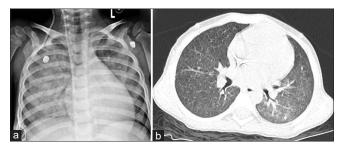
Chest X-ray showing bilateral fluffy opacities (a) and computed tomography (b) thorax showing bilateral diffuse ground-glass opacities in interstitial pattern favoring cytomegalovirus pneumonia
